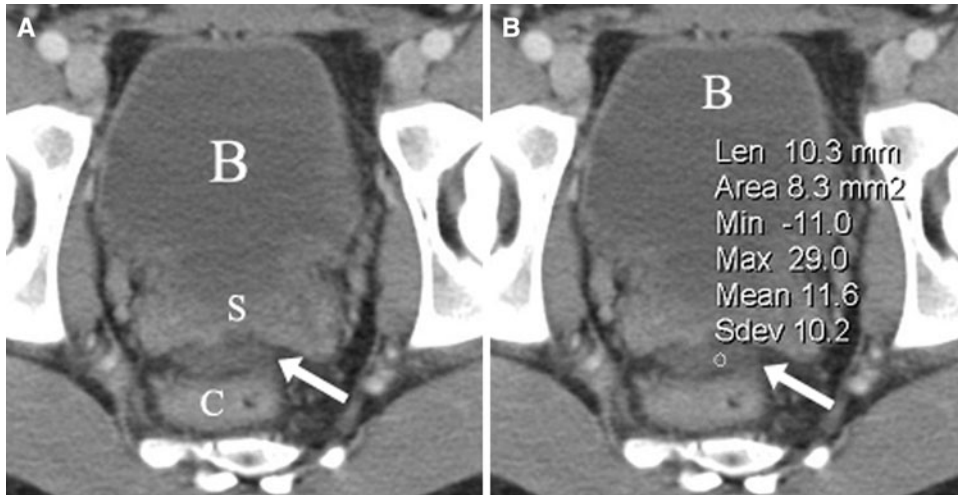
A 34-year-old male status post-blunt abdominal trauma. A Contrast-enhanced CT of the pelvis demonstrated a small amount of free fluid (*arrow*) posterior to the seminal vesicle (*S*) and anterior to the rectum (*C*). Bladder (*B*) is noted. B Contrast-enhanced CT of the deep pelvis
